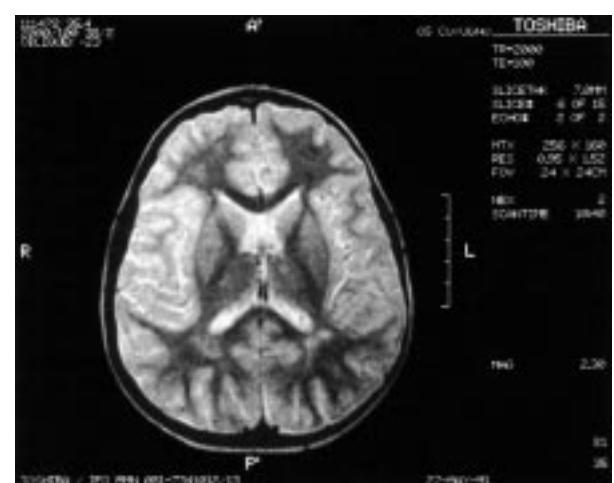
(a, b, c). Proton density weighted magnetic resonance images, showing a diffuse and inhomogeneous area of hyperintense signal encompassing the mesial aspect of both temporal lobes. The hyperintensity includes the head of the hippocampus and the parahippocampal gyrus in both sides (a, b), the entorhinal area and, partially, the amygdala of the right side (b). T2 weighted magnetic resonance image (c) showing multiple small and confluent areas of hyperintense signal in the retrotrigonal white matter of both sides.
